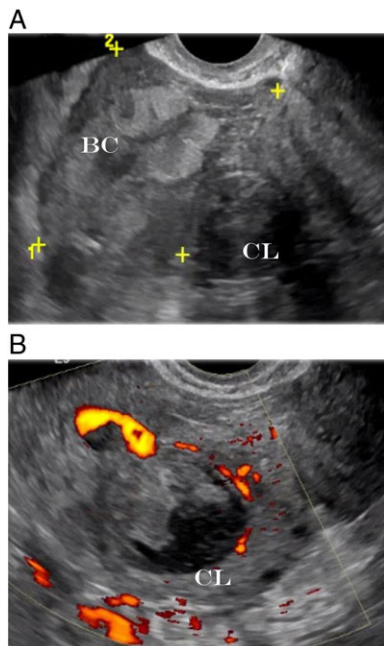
Inhomogenous adnexal mass (patient 11) mistaken for ectopic pregnancy. A complex mass (A) composed of a hemorrhagic corpus luteum cyst (CL) and blood clots (BC) surrounding the ovary that can resemble an ectopic pregnancy. Adding color Doppler (B) might not be beneficial, as corpus luteum and ectopic pregnancy share a similar appearance.
